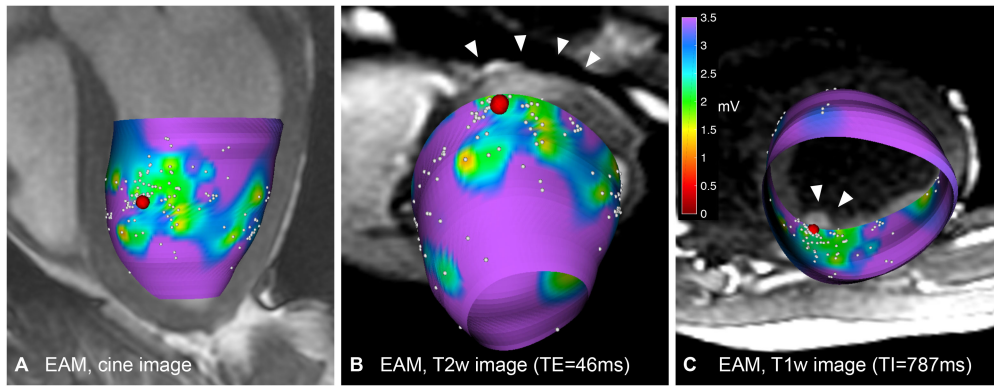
EAM of the LV after ablation - (A) EAM overlaid on a cine image (red point=location of catheter tip during ablation, based on active MR tracking, white points=EGM recording sites). (B) Alignment between EAM and T2-weighted MR. Arrowheads indicate the approximate extent of edema (26.5 mm). (C) Alignment between EAM and T1-weighted MRI. Arrowheads indicate the approximate extent of the RF lesion (7.8 mm). EAMs all use the same color map (≥ 3.5 mV=purple, normal myocardium).
